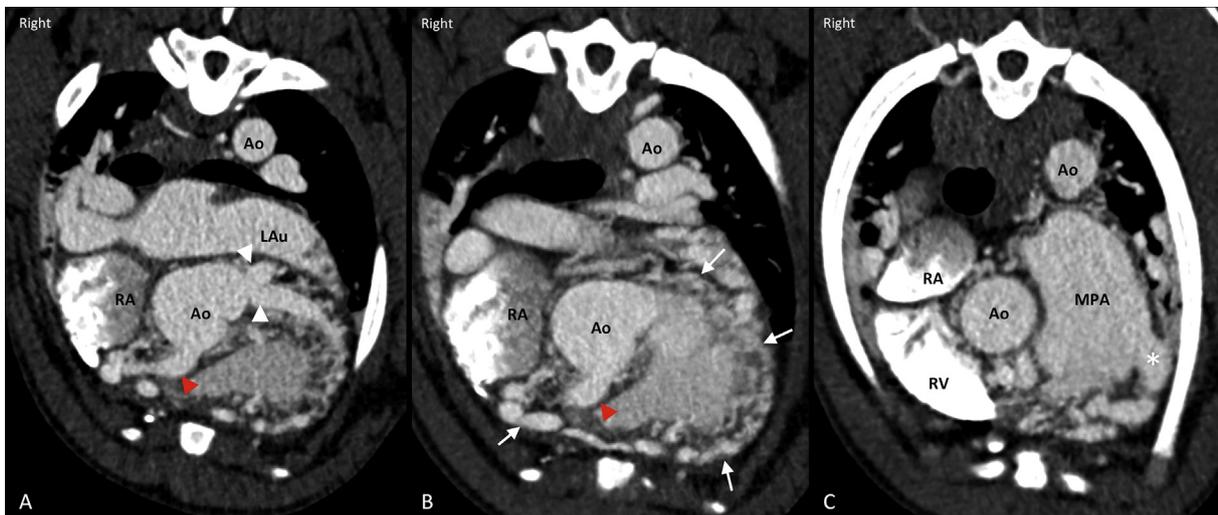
Transverse CT images from caudal to cranial (A–C) at the level of the heart base during levophase. A) Arising from the aortic sinuses, the right (red arrowhead) and left (white arrowheads) coronary arteries connect to B) a multitude of tortuous vessels (arrows) which in turn C) form a single vessel feeding into the main pulmonary artery (asterisk). Images were acquired in diastole, and streamlining artefact is visible in the right atrium. Abbreviations: Ao, aorta; LAu, left auricle; RA, right atrium; RV, right ventricle; MPA, main pulmonary artery; CT, computed tomography.
